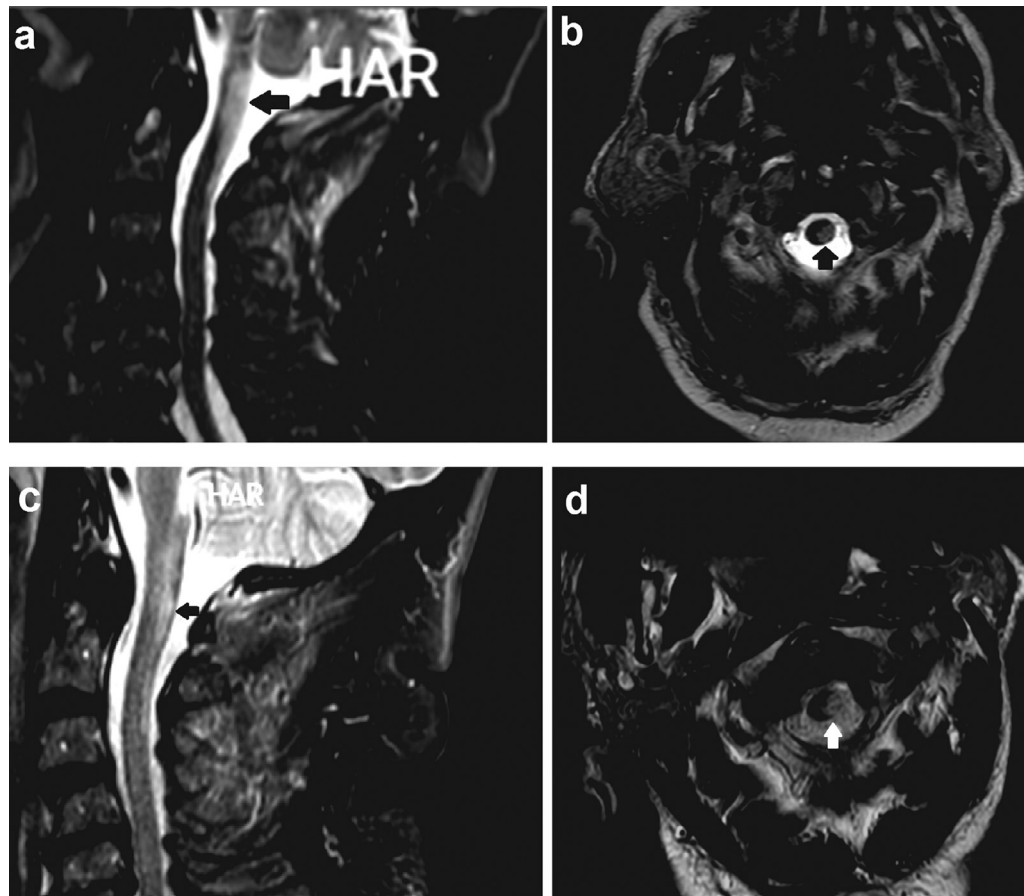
Cervical spinal cord T2-weighted MRI, disclosed a longitudinally extensive T2-hyperintense lesion in sagittal view (black arrow in A) without GAD enhancement (not shown here) from cervico-medullary junction to C3 level mostly on the left side of the cord in axial view (black arrow in B). Follow-up imaging after 2 weeks showed partial resolution of cervical spinal lesion in sagittal (black arrow in C) and axial (white arrow in D) views.
